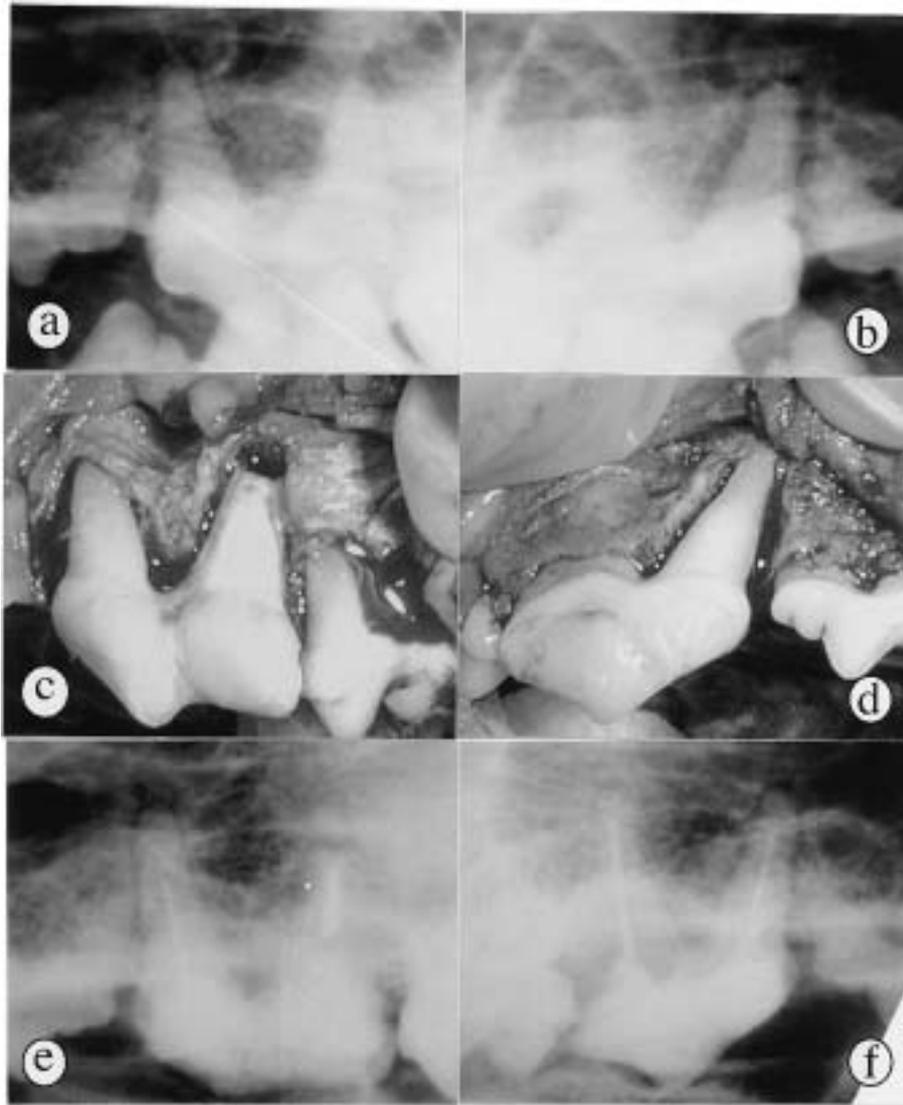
Dental radiographs and the clinical findings in case 1. (a): Radiograph of the maxillary left fourth premolar at the first admission. (b): Radiograph of the maxillary right fourth premolar at the first admission. (c): The apicoectomy and covering with glass ionomer cement of the distal root in the maxillary left fourth premolar in operation. (d): Clinical findings of the bone resorption around the distal root on the maxillary right fourth premolar in operation. (e): Radiograph of the maxillary left fourth premolar at 4 months postoperatively. (f): Radiograph of the maxillary right fourth premolar at 4 months postoperatively.
